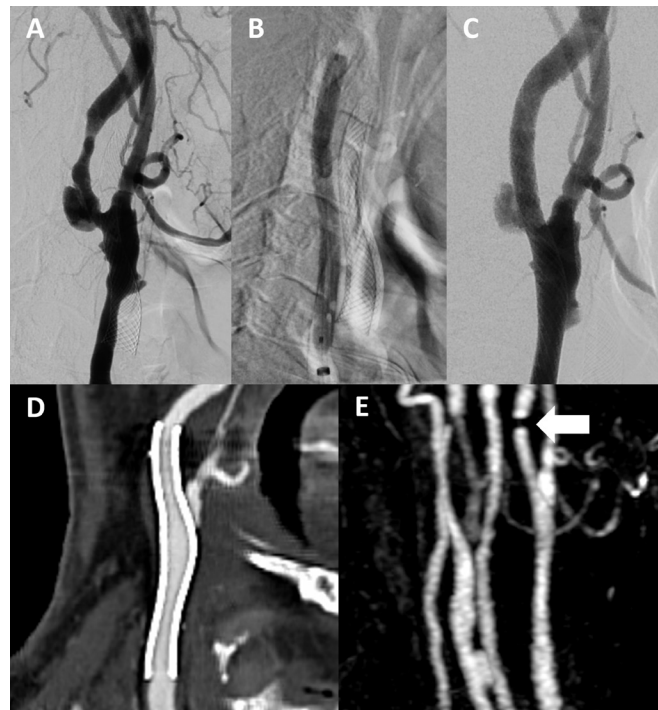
Primary angioplasty with a drug-eluting balloon (DEB) for postirradiated carotid stenosis showed no evidence of in-stent restenosis (ISR). An adult patient with left internal carotid artery and common carotid artery stenosis. (A) Preprocedural digital subtraction angiography (DSA) revealed a stenosis of 79.5%. (B) DEB angioplasty was successfully performed via a 5×60 mm Ranger balloon. (C) The control DSA demonstrated a residual of 10.8%, indicating technical success ($\leq 30\%$). (D) Long-term postprocedural CT angiography with curved multiplanar reconstruction performed 366 days and (E) contrast-enhanced magnetic resonance angiography performed 367 days after stenting revealed no significant ISR. The signal cancellation at the distal end was due to metallic artifacts (arrow).
